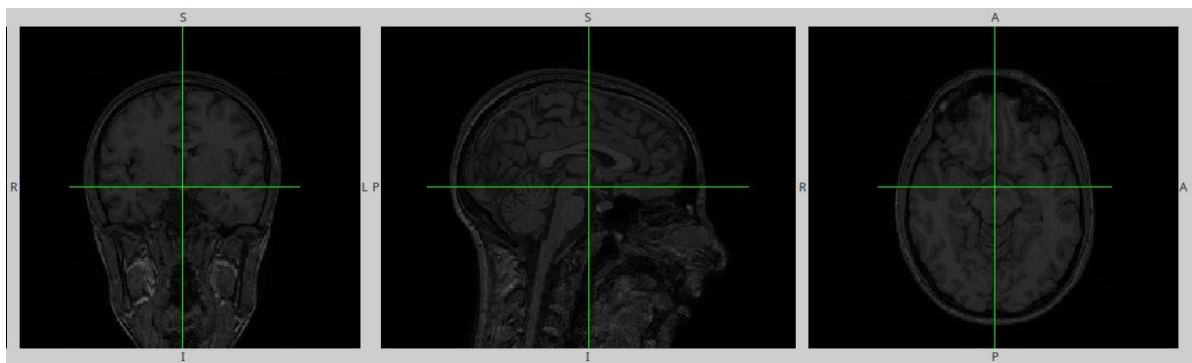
Coronal, sagittal and axial planes of T1-weighted image of a subject of the study.
